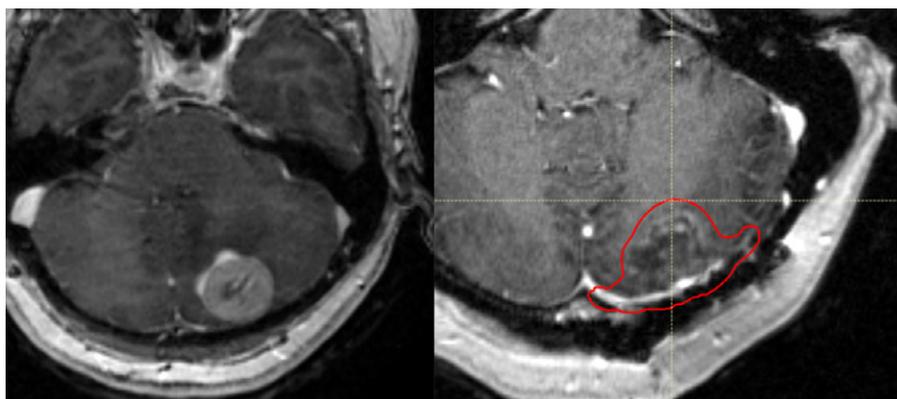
Pre- and postsurgical MRI of a left cerebellar metastatic lesion. The red line represents the treatment volume of the cavity.
